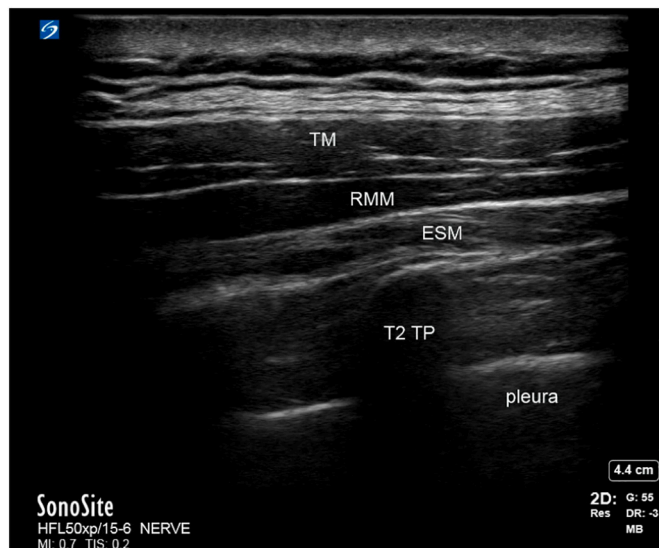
Ultrasound image of a T2 Thoracic Erector Spinae Plane Block.
